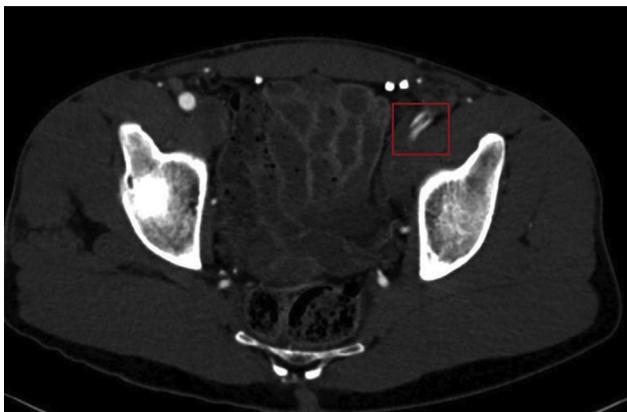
CTA was performed in the cycling position. The cycling position included flat and then tucked in position. The left iliac artery is shown with dissection versus endofibrosis (red box). CTA = computed tomography angiogram.
